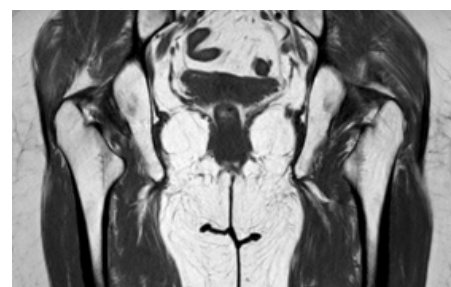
MRI of the hip joints reveals a reduced distance between the lesser trochanter of the femur and the right ischium.
